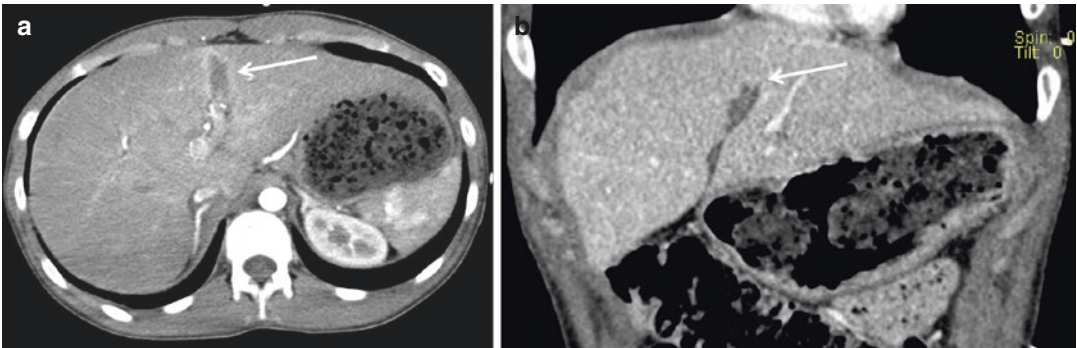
(a) Axial CT scan and (b) coronal reconstruction show a laceration of hepatic parenchyma between 1 and 3 cm deep (*arrows*)
